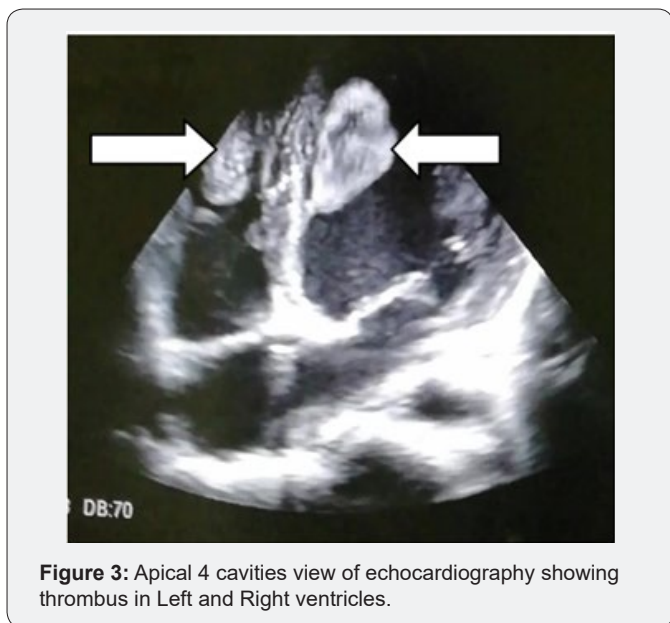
Apical 4 cavities view of echocardiography showing thrombus in Left and Right ventricles.
